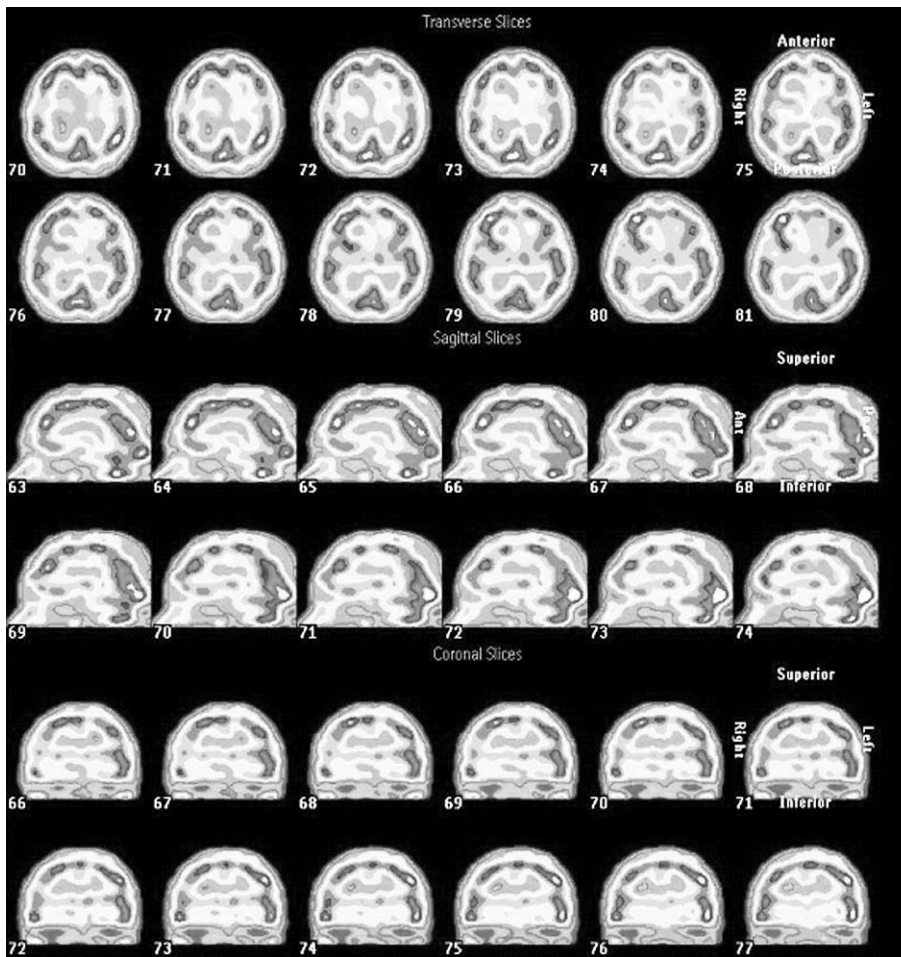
Single-photon emission computed tomography of the brain of patient Z. after endovascular intervention. The perfusion in the right hemisphere is improved.
